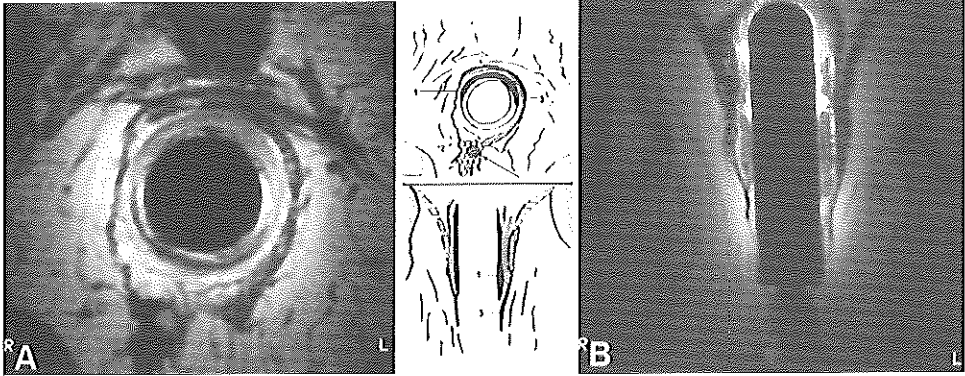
Generalized scarring*. Axial (A) and coronal MRI (B) in a male (45) with faecal incontinence after multiple operations for fistula-in-ano. The external (3) and a part of the internal sphincters (1) are replaced by scar tissue. Fistula (arrow) is still present.
